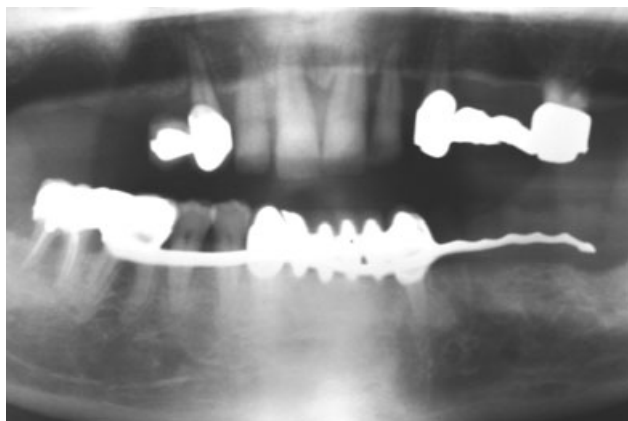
Initial radiographic situation.
